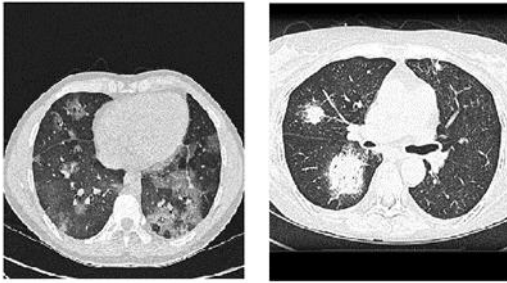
Abnormal chest CT scans with GGO and Halo sign
